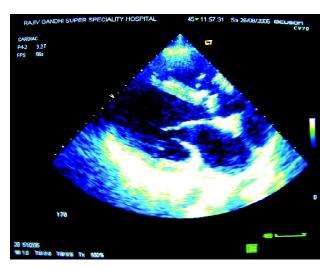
Echocardiogram showing the calcified aortic valve and npture of sinus of Valsalva.
